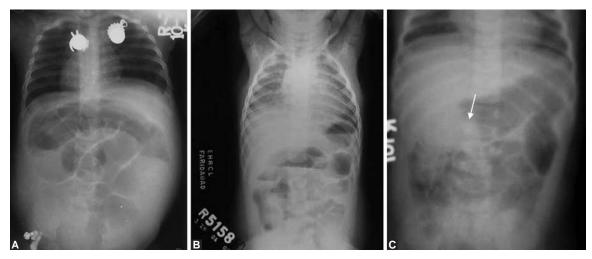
X-rays of abdomen: A, right iliac fossa empty; B, signs of intestinal obstruction; C, soft tissue mass (arrow). Normal X-ray does not rule out intussusception
